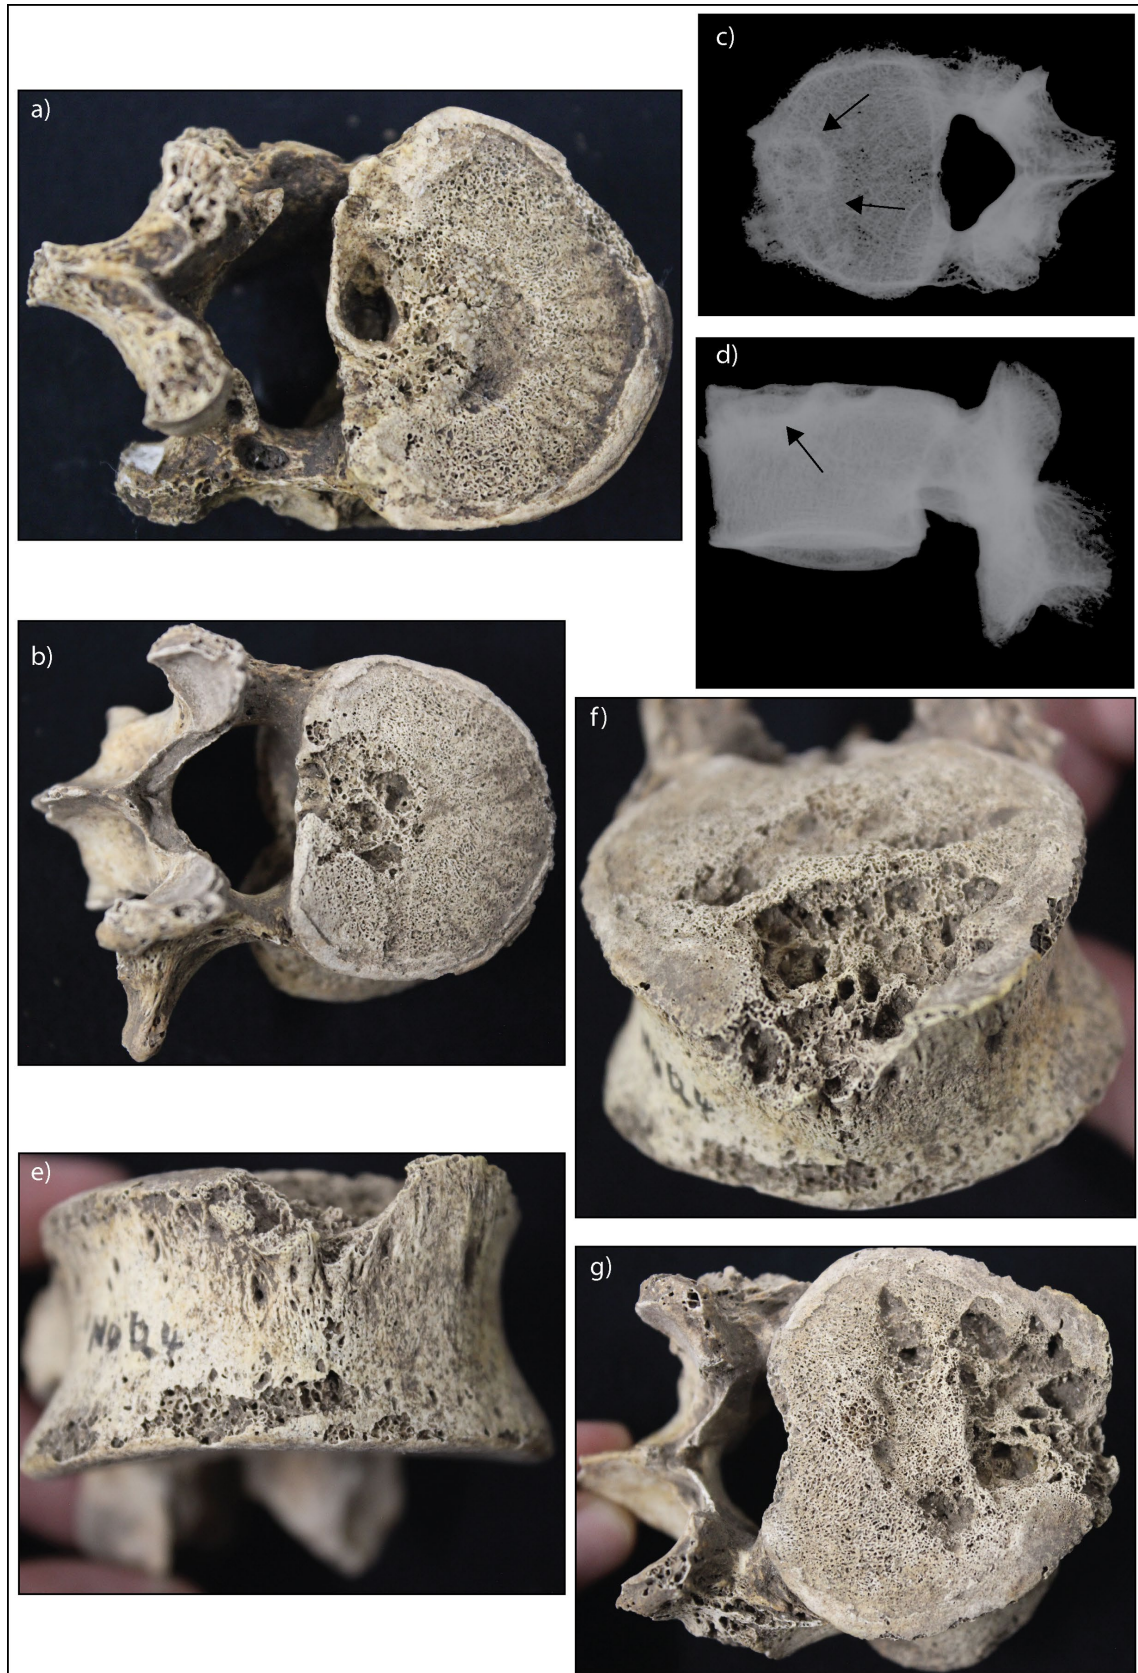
Osteolytic lesions of the vertebral bodies of Tsukumo 6, young adult female. a) Inferior vertebral body of the T12. Note the cloaca on the posterior margin indicating pyogenic infection. b) Superior vertebral body of the L1. c-d) radiographs of L2. Note the sclerosis of the lesion margins (black arrows). e-g) Superior vertebral body of L2. While there are burst fractures evident on the vertebral bodies, these do not appear to be related to the progression of the osteolytic lesion. Image: author's own
